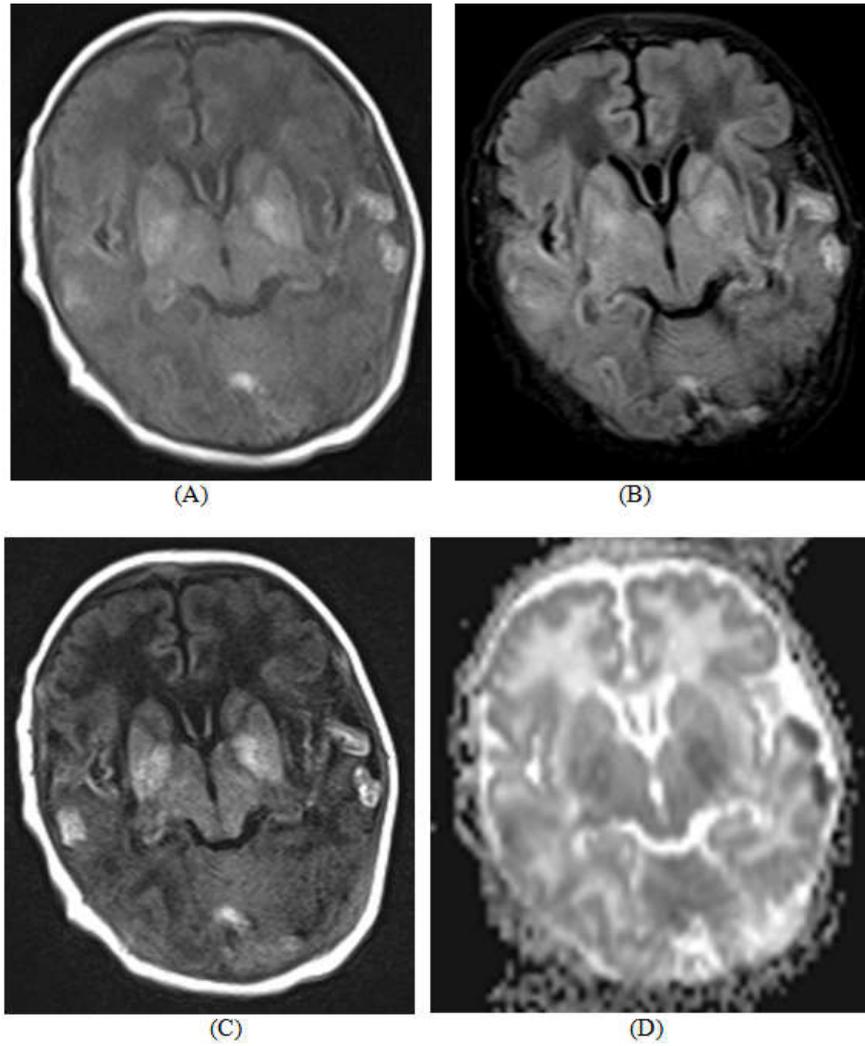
Hypoxic ischemic pattern in term infants (A) T1 FLAIR, axial (B) T2 FLAIR, axial (C) DWI sequence (D) ADC sequence
